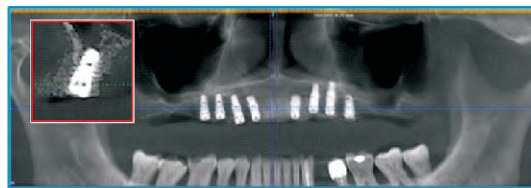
Post-operative orthopantomogram taken 1 week after the surgery. Inset picture showing the accuracy of the implant position in the bone (Region of 15) as planned virtually pre-surgically.
